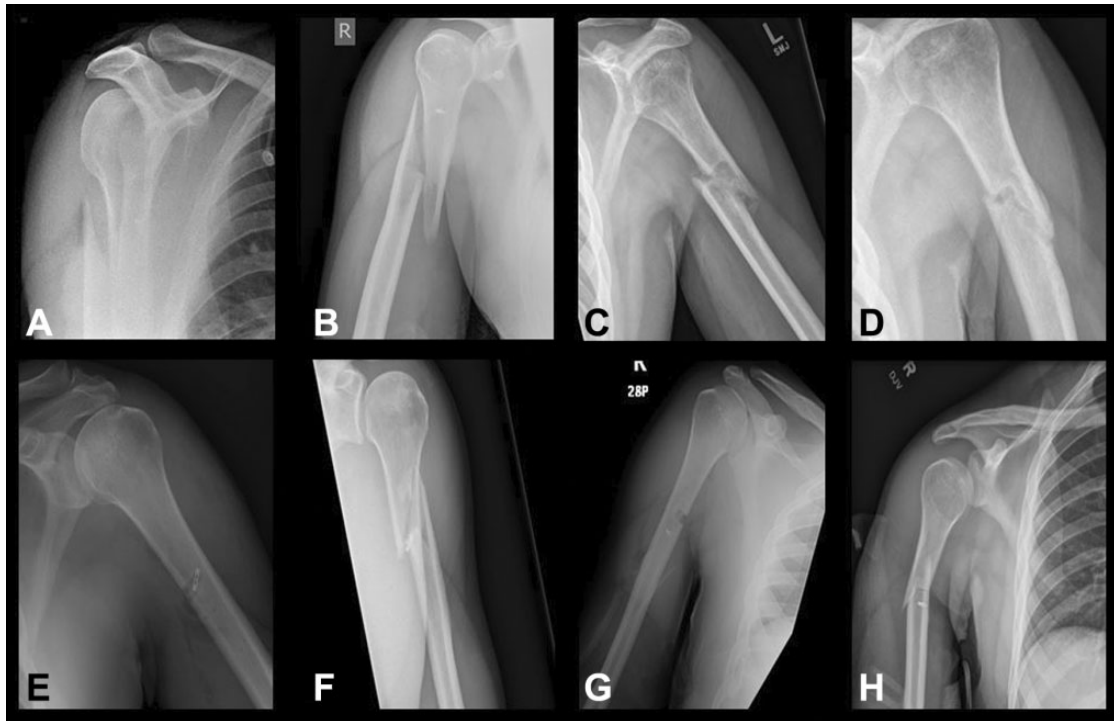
Orthogonal radiographs of fracture (A, B) after surgical site infection treated with removal of suture anchor fixation and (C, D) after biceps tenodesis with interference screw fixation. Postoperative and initial injury radiographs of (E, F) patient with cortical button fixation and (G, H) patient with suture anchor fixation.
